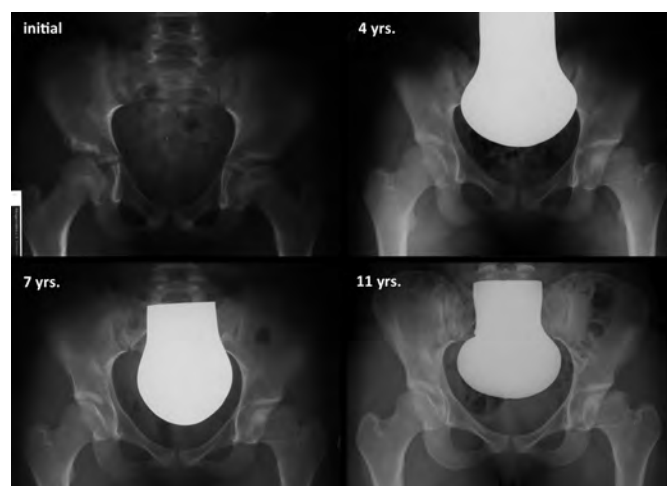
A consecutive series of anteroposterior pelvis radiographs acquired over an 11-year period are shown. On initial presentation (upper left), this 10-year-old female patient presented with clinical symptoms and radiographic evidence of Perthes disease and concomitant marginal hip dysplasia on the left side. In the light of acceptable hip joint congruity, this patient was treated conservatively with physical therapy. While containment of the femoral head was initially maintained, it became apparent that the central head portion underwent consecutive collapse, leading to the incongruent left hip joint with a too large, subluxated head depicted in the lower right corner.
